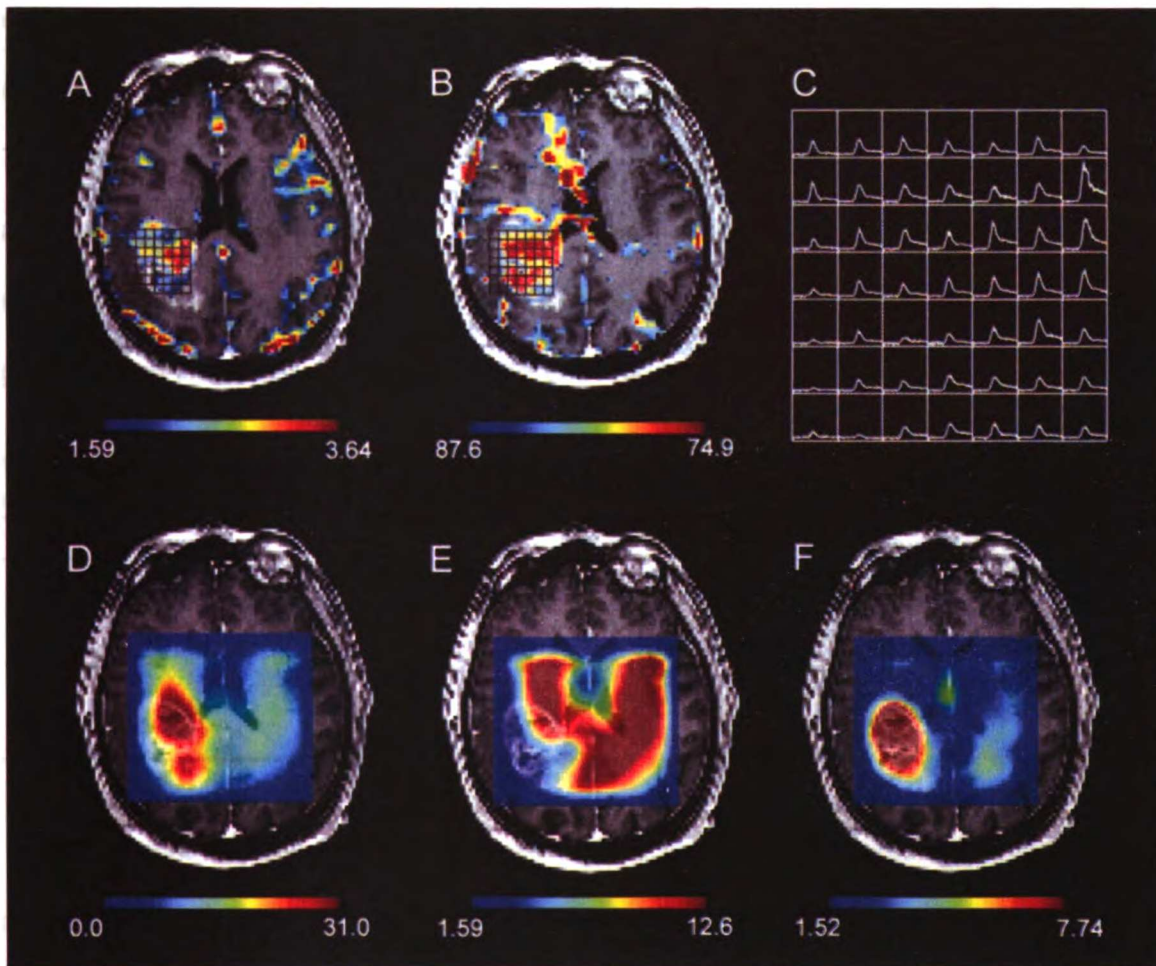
Perfusion-derived non-parametric maps of a) peak height and b) percent recovery overlaid on post-contrast T1-weighted images with c) corresponding $\Delta R2^*$ curves for a representative grade IV glioma. In d-f, corresponding metabolite maps of d) choline, e) creatine, and f) lactate.
